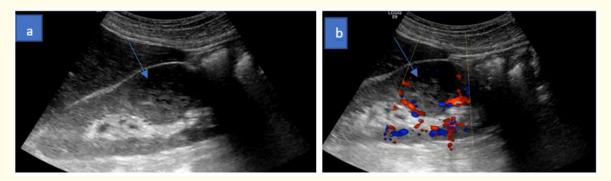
a-Longitudinal section of the right kidney on ultrasound: A mid renal isoechogenic mass with irregular outlines. b-Mass hypervascularised at the doppler color.
